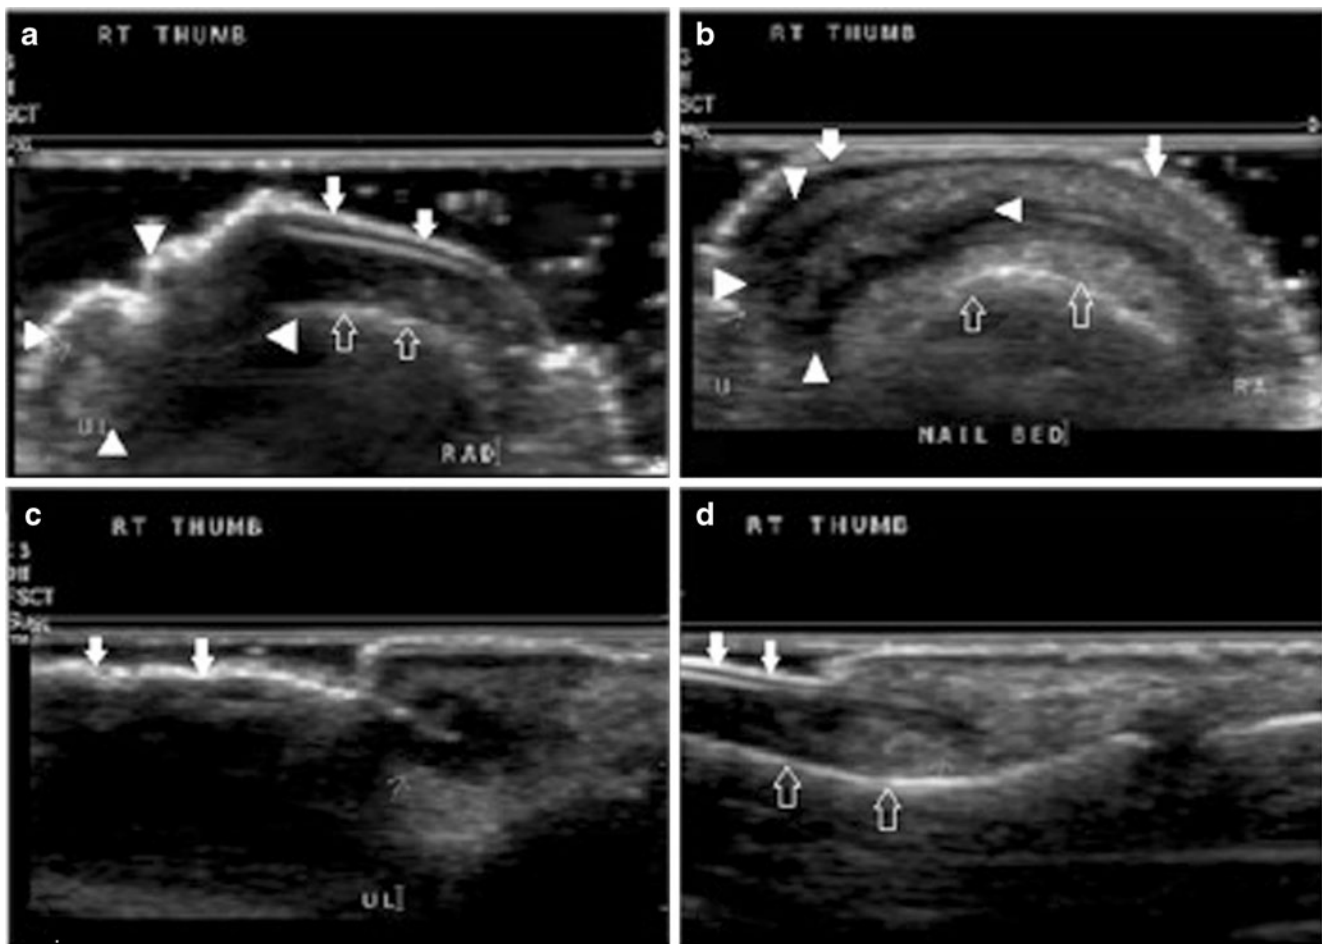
Infection. Ultrasound shows the right thumb in transverse and sagittal planes showing fungal infection of the nail bed. a Transverse image through germinal matrix demonstrating the infected thickened matrix on the ulnar aspect. The overlying nail fold also demonstrates thickening, and the low echogenicity indicates oedema. Distal attenuation leads to ill-defined deeper cortical margin. Normal anatomy is well demonstrated on the radial side from skin surface to the bone. b Transverse image just distal to the nail fold obtained with coupling to get standoff demonstrated normal anatomy on the radial aspect from the nail surface to the bone. Both superficial and deep surfaces are clearly seen as
